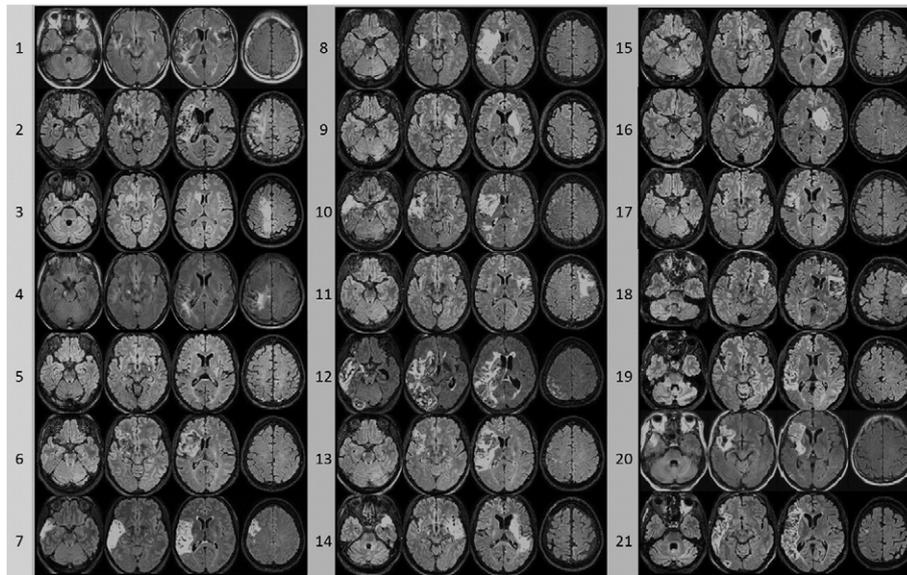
Four axial slices representative showing stroke lesion extent in 21 patients (FLAIR images).
